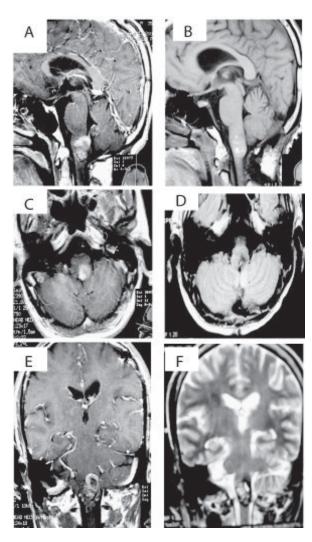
(Case 5): Preoperative MRI(A,C,E) and early postoperative CT scan(B,D,F)of same patient showing some residual cavernous angioma in Medulla oblongata.
